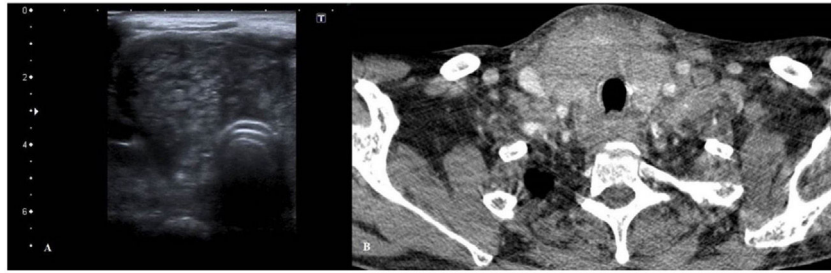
(A) Thyroid ultrasound. Enlarged right thyroid lobe with no clear nodularity. Heterogeneous echogenicity with a tiger-striped appearance. Lobe measuring 39 mm in length. (B) CT scan of the neck. Generalised enlargement of the thyroid gland with a heterogeneous appearance. Bilateral pathological cervical lymphadenopathy. Decreased tracheal calibre.
